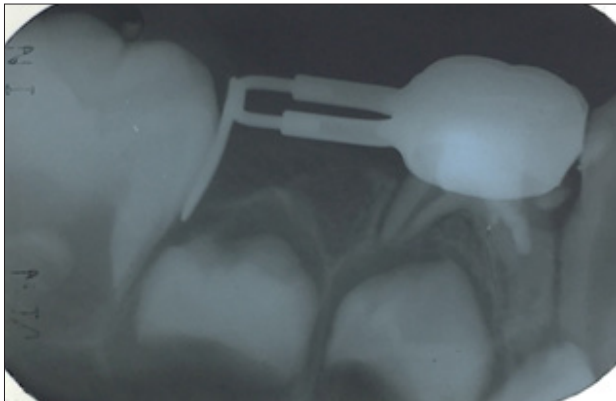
12 month post operative radiograph with distal shoe space maintainer
